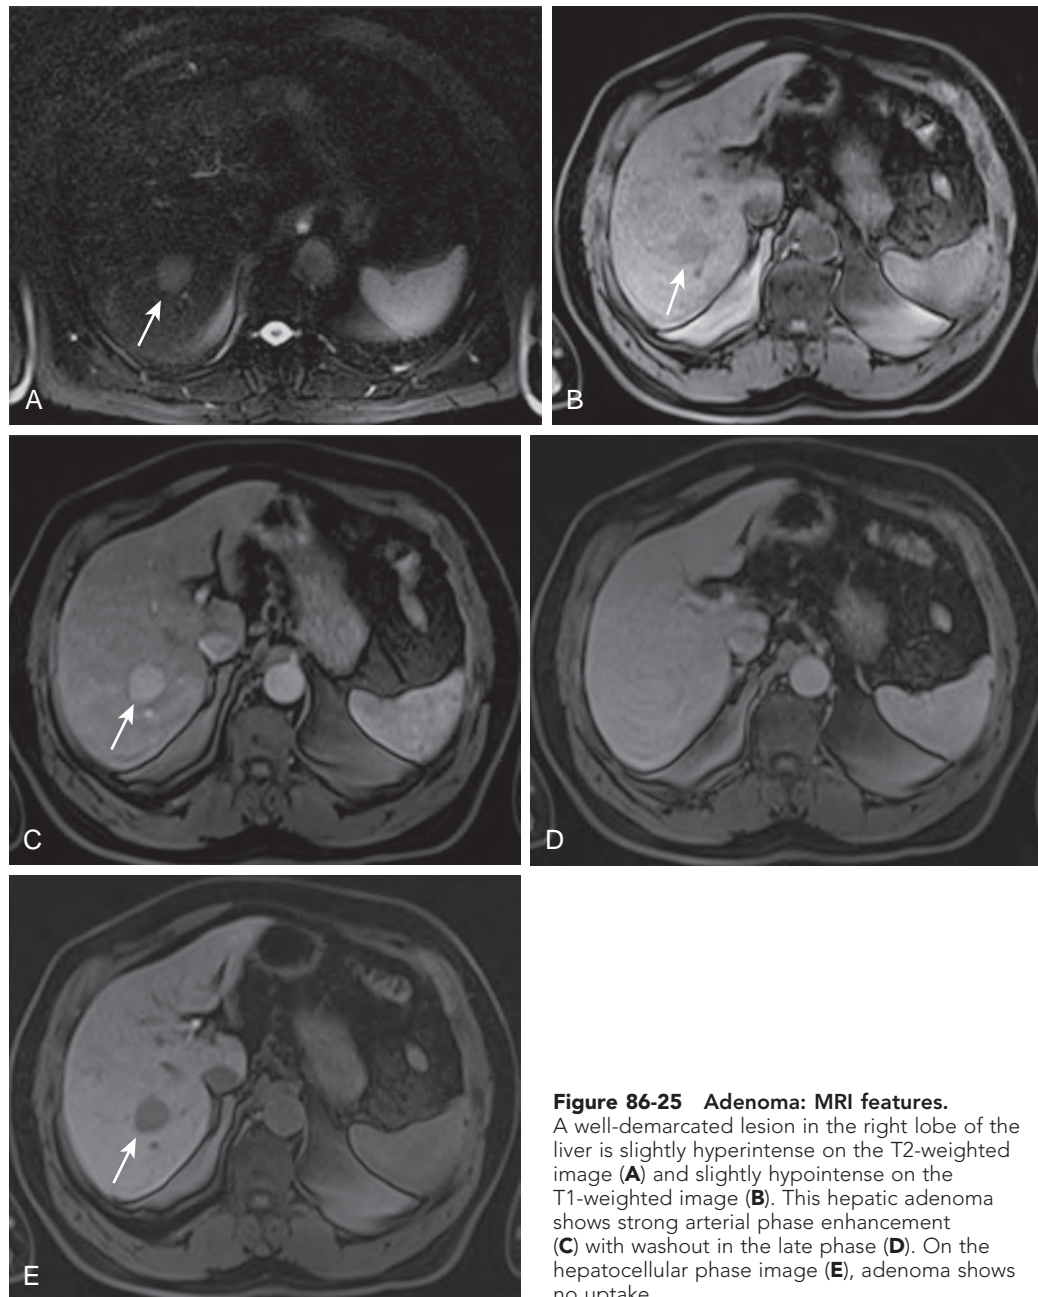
Adenoma: MRI features. A well-demarcated lesion in the right lobe of the liver is slightly hyperintense on the T2-weighted image (A) and slightly hypointense on the T1-weighted image (B). This hepatic adenoma shows strong arterial phase enhancement (C) with washout in the late phase (D). On the hepatocellular phase image (E), adenoma shows no uptake.
